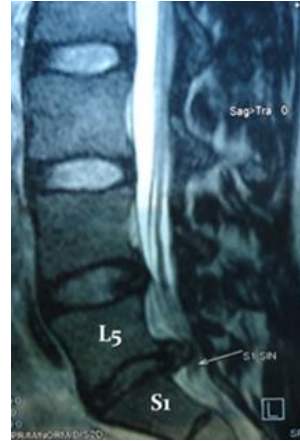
MRI image of disc herniation at L₅-S₁ level
